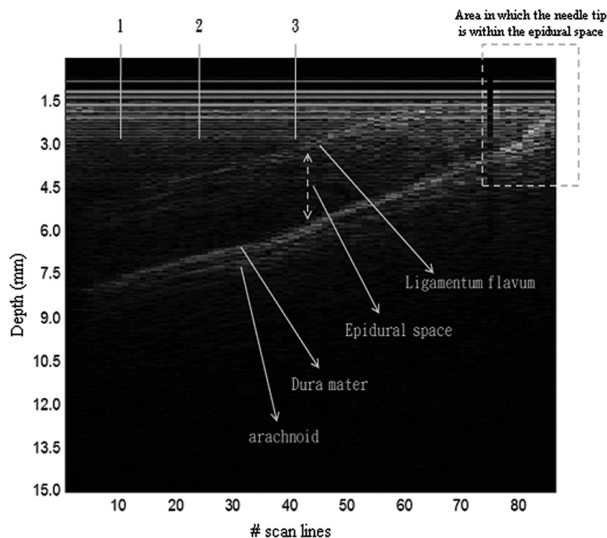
A two-dimensional depth-scan image of the epidural space formed by 85 ultrasound A-mode lines recorded at different depths during the insertion of the epidural needle into the epidural space. Locations 1, 2, and 3 show that the tip of the needle transducer is 7.5–6 mm away from the dura mater. The right corner area shows the tip of the needle transducer is inserted into the epidural space.
